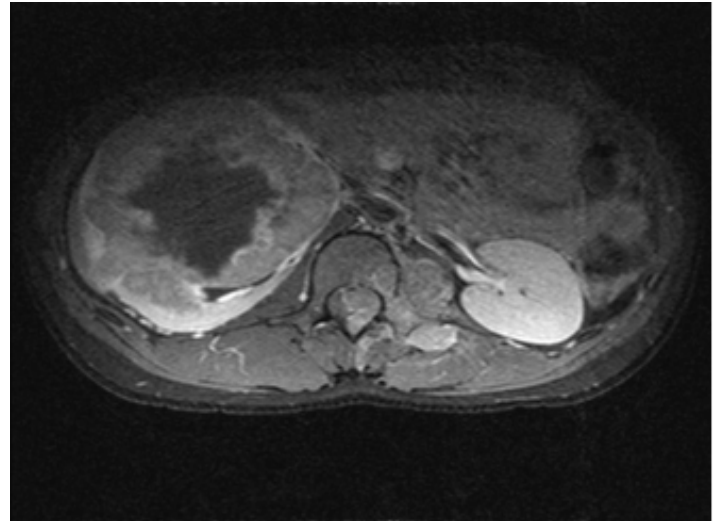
MRI abdomen showing a mass arising from the lower pole of the right kidney.
